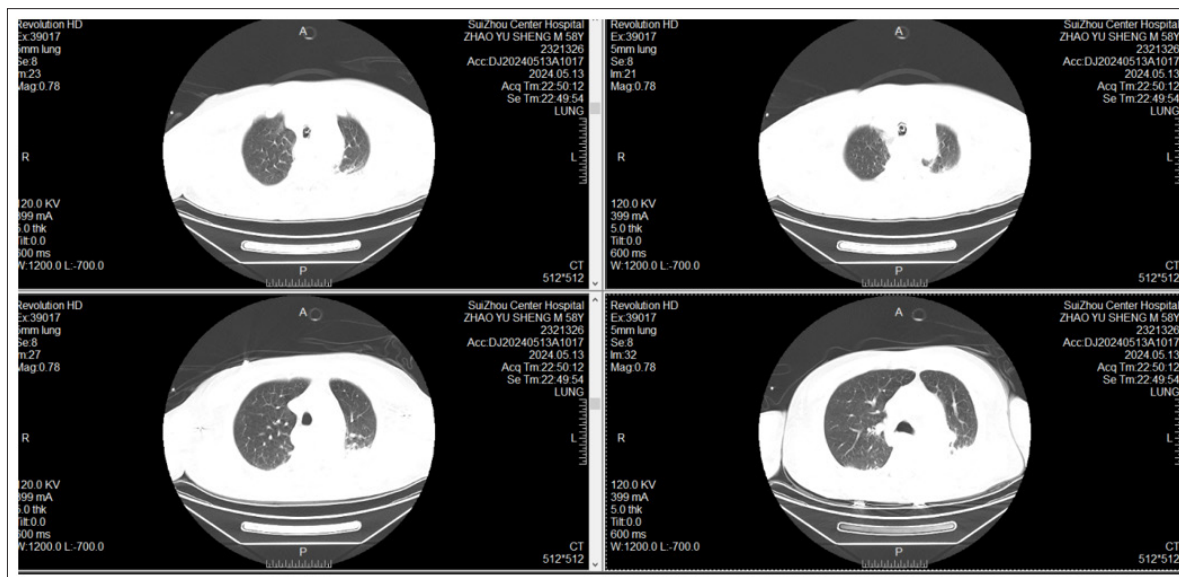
Lung CT on May 13 showed multiple ground glass nodules in the lower lobes of both lungs, with no obvious nodules
